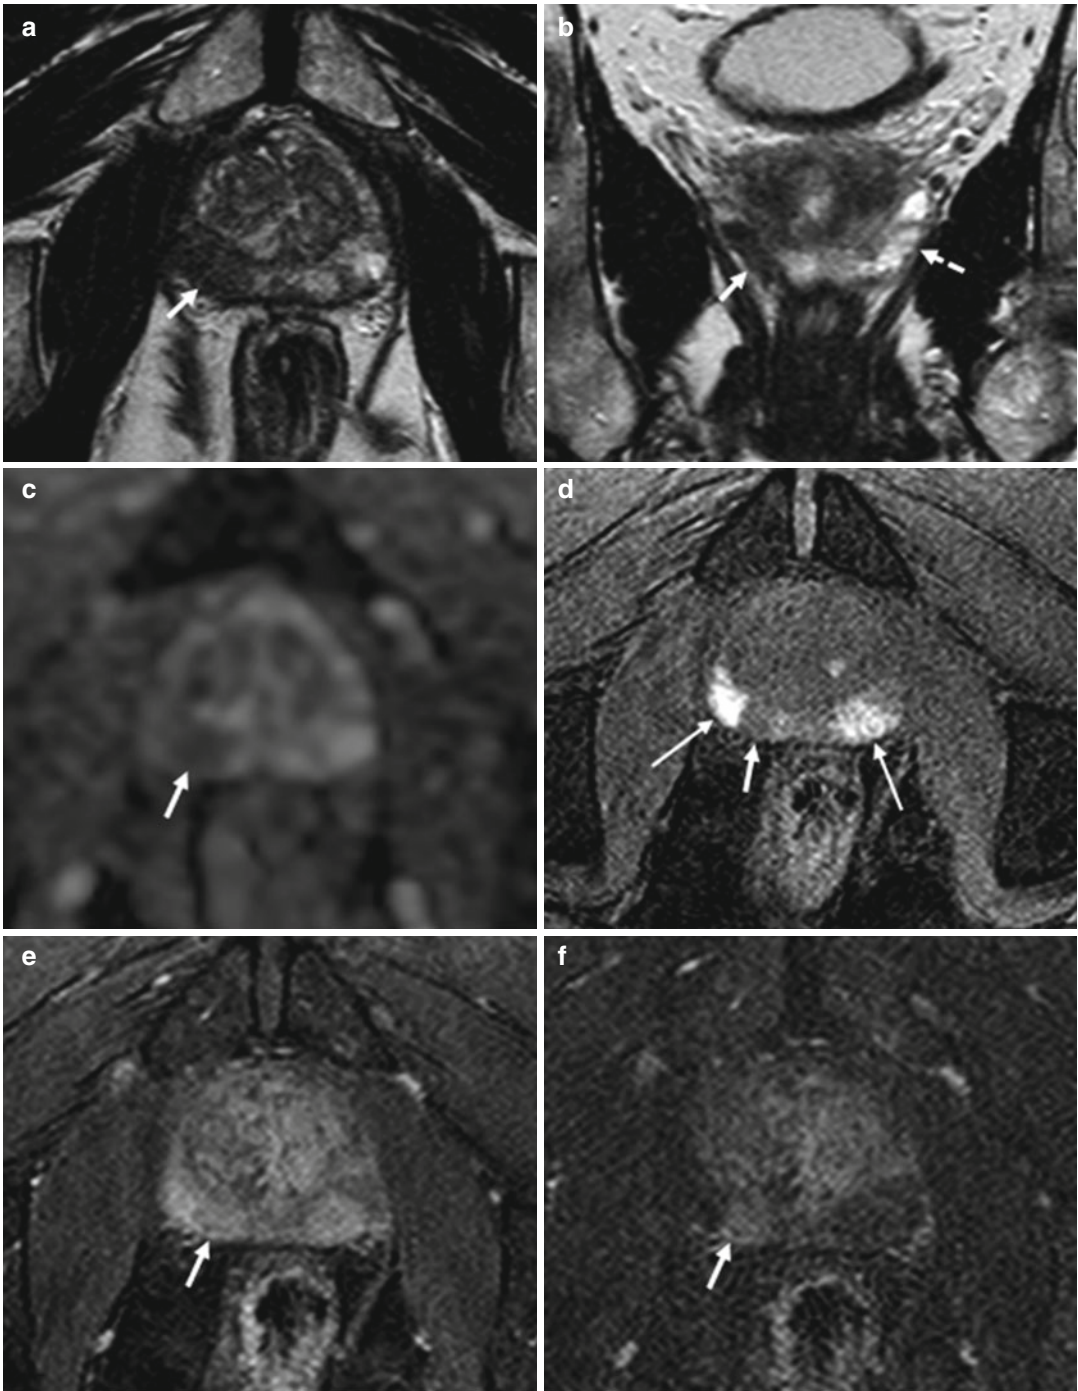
(a–f) 64 years old, recently underwent prostate biopsy. Axial (TR: 4074; TE: 100) (a) and coronal (TR: 4013; TE: 100) (b) T2-weighted sequences show hypointense area in the peripheral zone of the right lobe (arrows), more appreciable when compared to the physiologic hyperintensity in the left lobe (dashed arrow). On ADC sequence (c), the nodule (arrow) appears hypointense while on axial T1-weighted (TR: 8,9; TE: 4,3) sequence (d) is more hypointense than the remaining peripheral zone (long arrow) that
